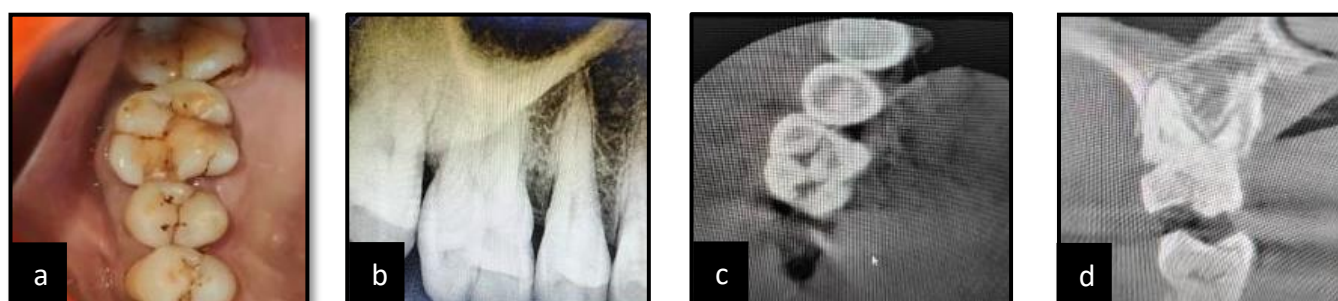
(a) Preoperative picture, (b) Preoperative radiograph, (c) Cone beam computed tomography (CBCT) showing the fracture line extending mesially and buccally, and (d) cracked line also towards the pulp space
